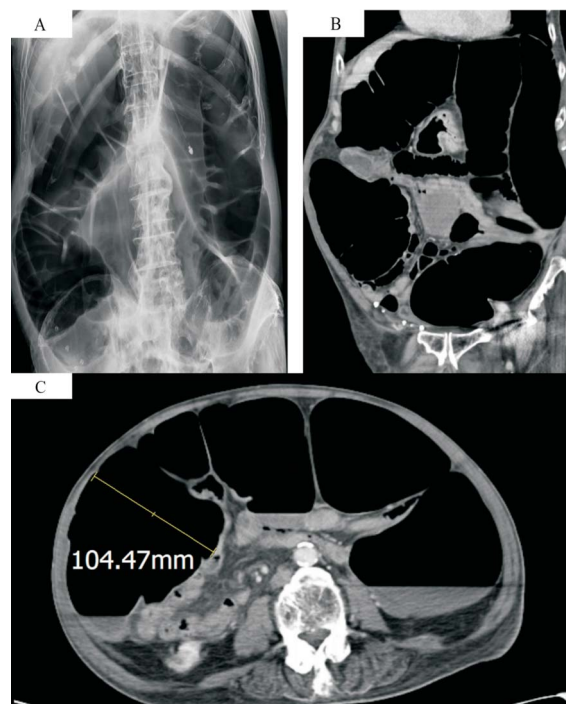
A: Abdominal plain film revealed exuberant colonic dilatation. B: CT showed distention of the entire colon. C: CT showed distention of the entire colon, with a maximum calibre of 104 mm.
